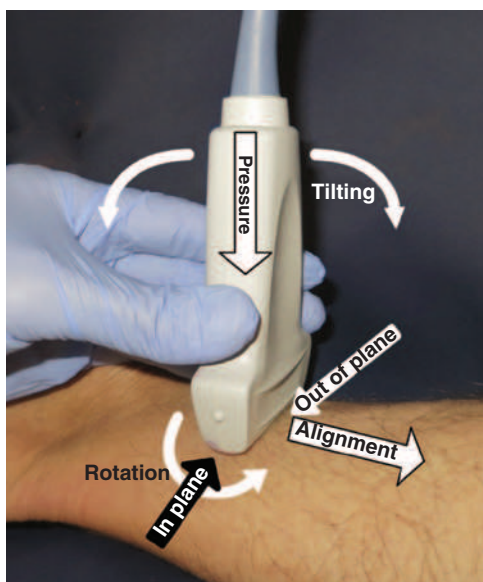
Ultrasound transducer handling terminology. An ultrasound-guided nerve block can be performed either in-plane, so that the entire shaft of the needle is visualized in its longitudinal axis, or out-of-plane (perpendicular to the scanning plane). Standard ultrasound probe maneuvers to improve imaging are pressure, alignment, rotation, and tilting.
